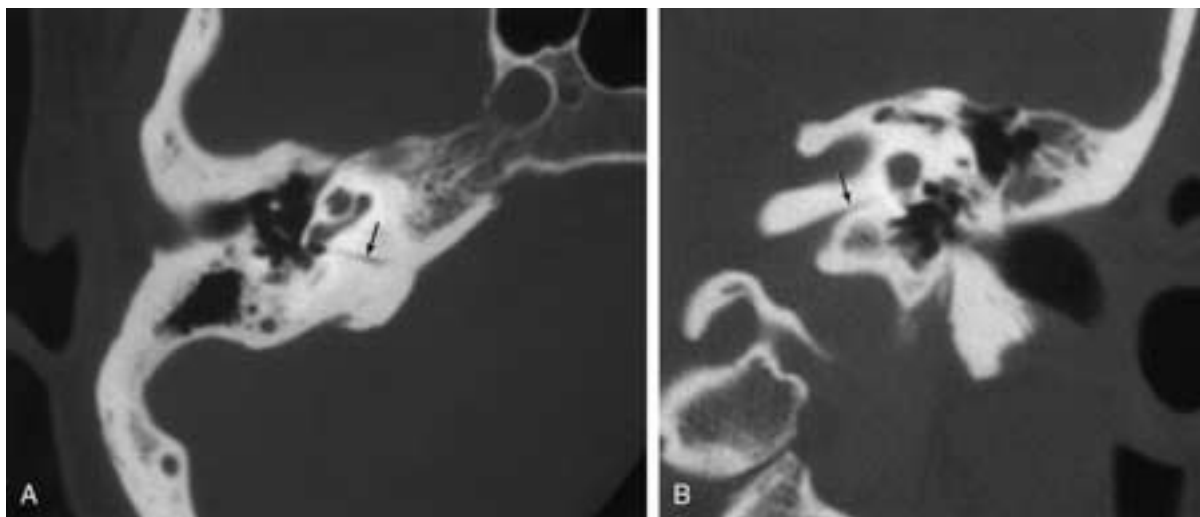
Pseudo-fracture, cochlear aqueduct. A, Axial CT image. B, Coronal CT image. These magnified CT images clearly demonstrate a normal-appearing cochlear aqueduct (*arrows*), which should not be confused with a fracture.
